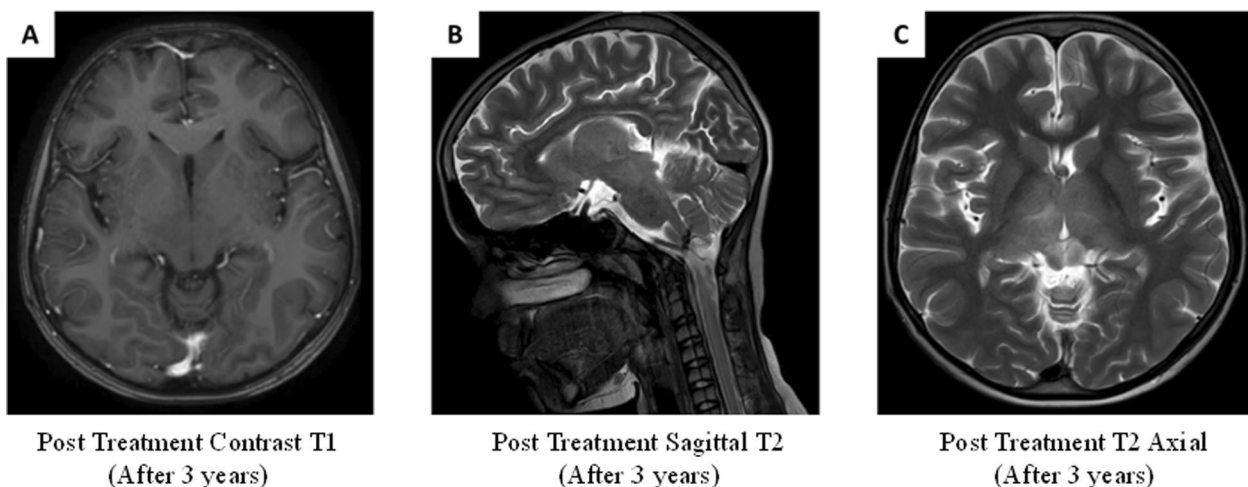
Post-treatment MRI of the brain showing diffuse intrinsic pontine glioma
